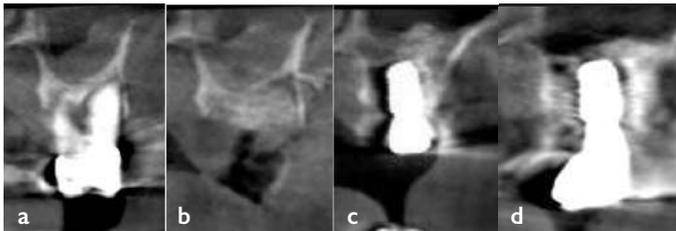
CT scans taken before extraction of tooth #27, after socket preservation, after implant placement, and after completing the final restoration, respectively
